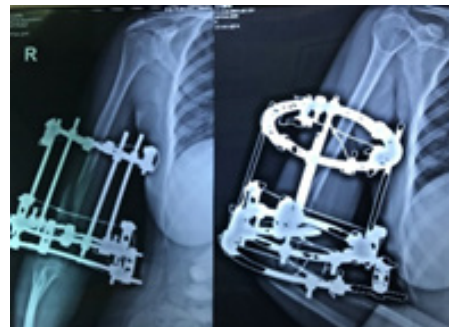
Post-operative x-ray after Ilizarov operation.
